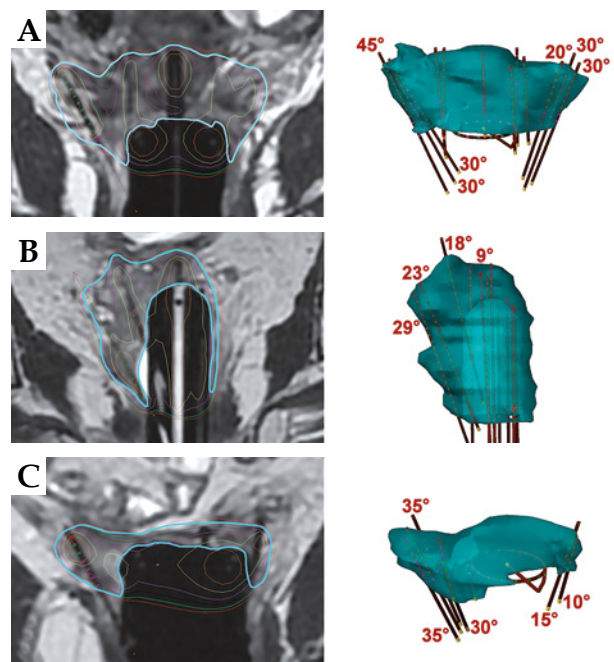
MRI of three different types of 3D implants (left side) with corresponding CTV- T_{HR} (cyan color), with active channel source positions and angles for oblique needles (right side). A) Tandem, ring, and add-on for parallel and oblique needles; B) Multi-channel vaginal cylinder for the implantation of parallel and oblique needles; C) Ring for the interstitial implantation of parallel and oblique needles; B and C) Implants used in patients after hysterectomy
